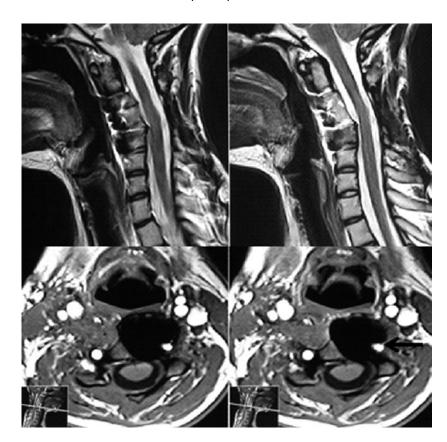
T2 (above) and T1 with gadolinium contrast (below) magnetic resonance imaging shows total resection of the tumor. The arrow underlines the left vertebral artery.
